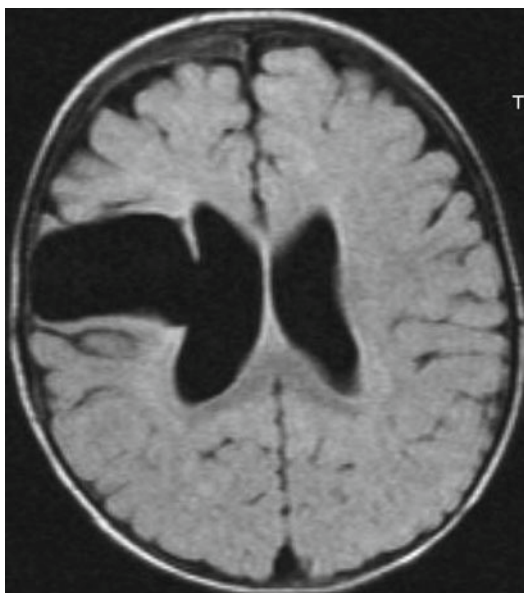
Postoperative MRI showing resection of seizure focus
